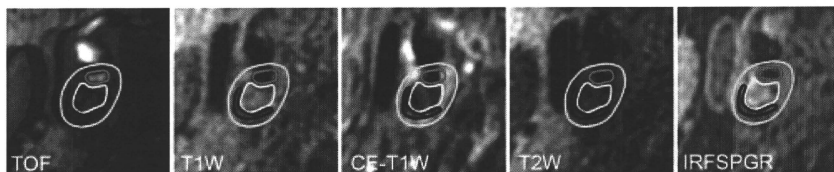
An example of images with overlays by MRI—plaque view. Red indicates luminal boundary; light blue, outer wall boundary; the area outlined by yellow appears iso- to hyperintense on T1-weighted image and hypointense on contrast-enhanced T1-weighted image indicating LR/NC; the area inside black line appears hypointense on all the images, indicating calcification. TOF indicates time of flight; T1W, T1-weighted; CE-T1W, contrast-enhanced T1-weighted; IRFSPGR, inversion recovery fast spoiled gradient recalled.
